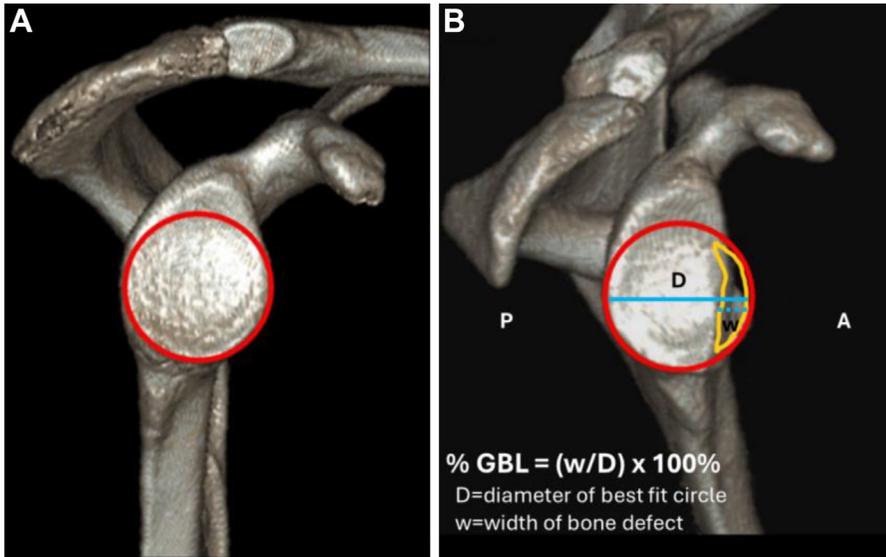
A CT reconstruction with 3D reformat en face view of the glenoid demonstrating a best-fit circle drawn along the inferior portion of the glenoid shown on an intact glenoid without bone loss (A) as well as on a glenoid with attritional bone loss and medialized bone on the glenoid neck (B). A, anterior; P, posterior.
